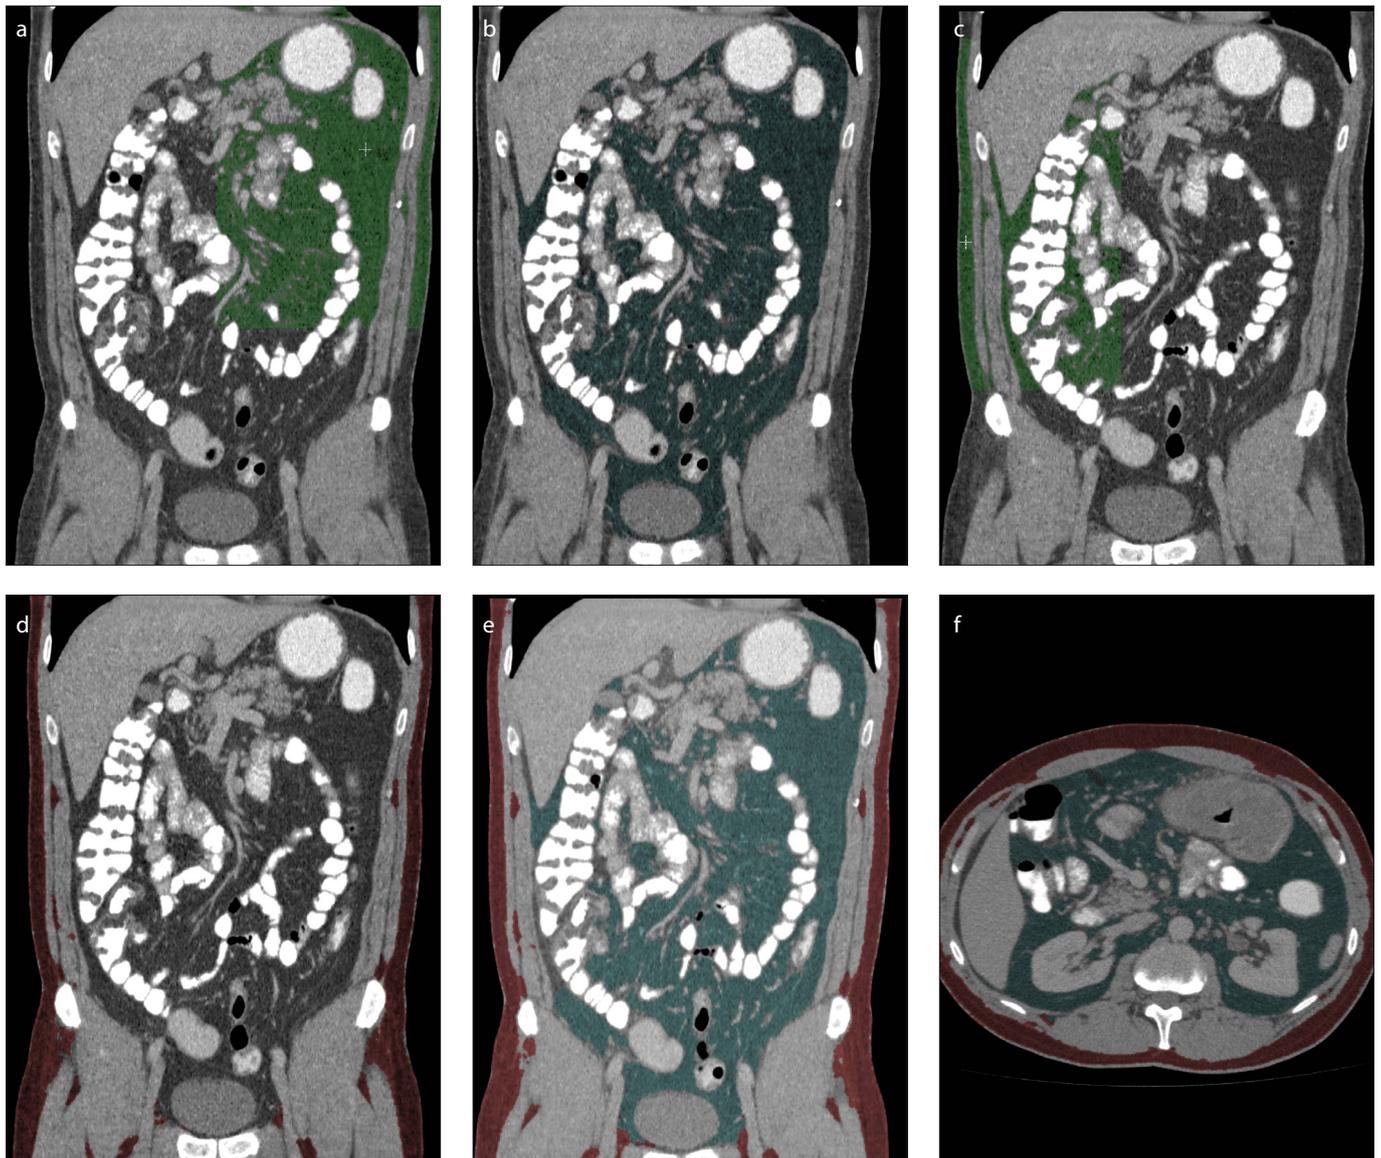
a–f. Abdominal adipose tissue measurements by using specialized software. Coronal (a–e) and axial (f) oral- and IV-contrasted abdominopelvic CT images. Image (a) shows marking of the visceral abdominal adipose tissue by using a plus sign (+) provided by the software. After the marking, similar density areas are determined, and image (b) is formed by the software. Image (b) demonstrates the final visceral adipose tissue mass (*dark green area*) which is selected by the software after manual editing by the researchers. Image (c) shows marking of the subcutaneous abdominal adipose tissue with a plus sign (+). After the marking, similar density areas are determined, and image (d) is formed by the software. Image (d) shows the final subcutaneous adipose tissue mass (*dark red area*), which is selected by the software after manual editing by the researchers. Images (e) and (f) demonstrate the visceral (*dark green area*) and subcutaneous (*dark red area*) abdominal adipose tissue together. On image (f), a transverse colon mass is readily seen.
